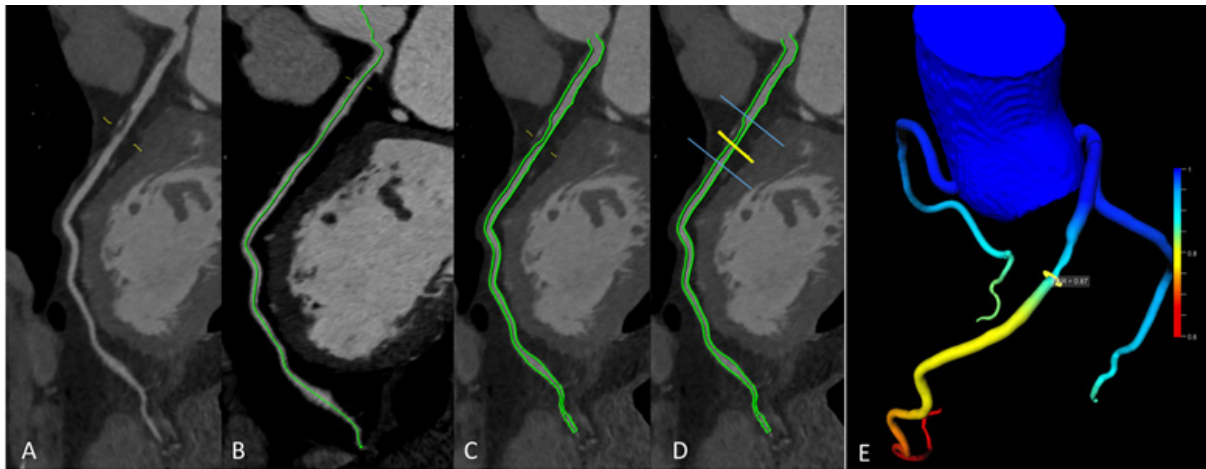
Steps to calculate FFR_{CT} using the $cFFR$ software. A) Visual detection of the coronary lesion. Definition of centerline B) and lumen contours C) using the $cFFR$ software D) definition by the operator of the lesion borders and the point of higher lumen reduction. E) FFR result at the point with higher lumen reduction shown in the coronary tree (after determining the centerline and lumen contours in the 3 main coronary arteries: LAD, LCx, and RCA).
